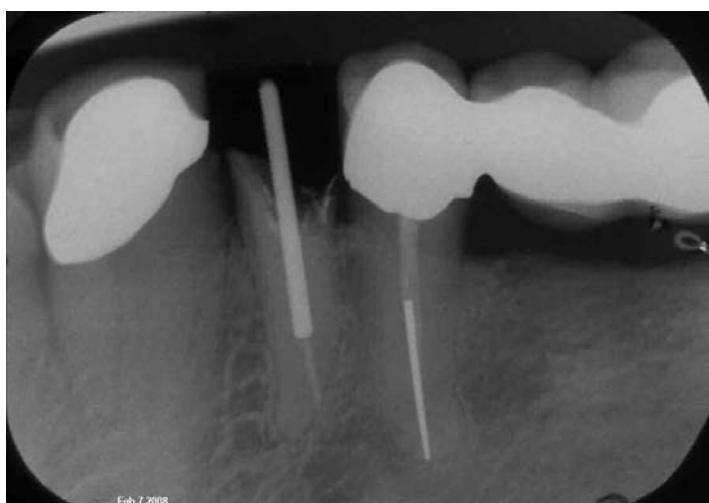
Parallel sided serrated post (parapost #4) .031 inch self tapping pin added for retention – not visible in radiograph.
